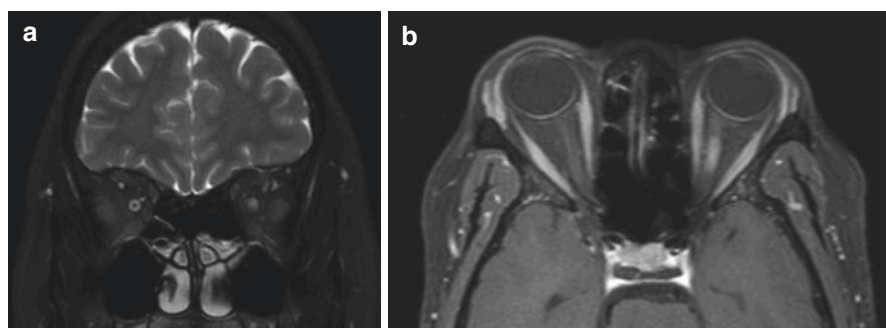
MRI (a) coronal STIR image showing high signal within the left optic nerve, and (b) axial T1 weighted scan following injection of gadolinium showing a long region of enhancement of the left optic nerve
